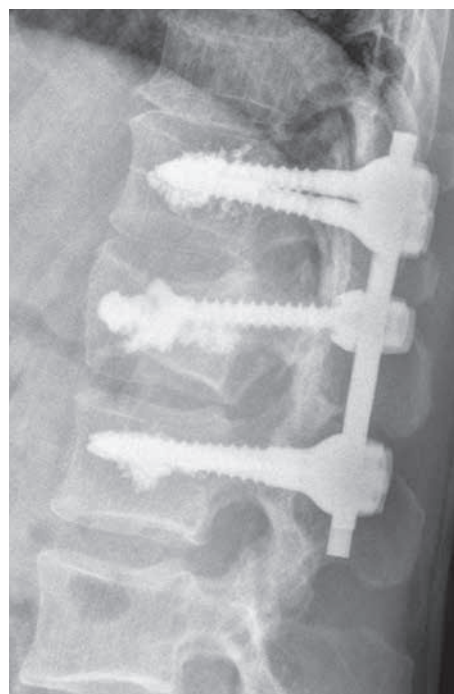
Lateral roentgenogram two days after surgery of the patient showing excellent alignment following short fixation and adequate vertebral body reduction.
